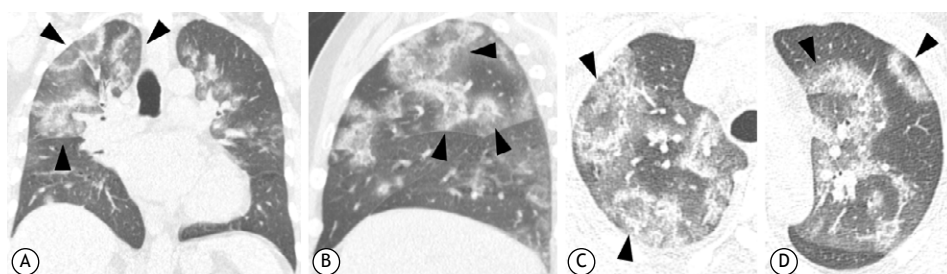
Images in coronal (A), sagittal (B), and axial (C and D) reconstructions from multidetector CT, showing multiple diffuse ground glass areas in both lungs, surrounded by partial or complete rings of consolidation, known as the reversed halo sign (arrows), in a 56-year-old male patient with COVID-19 pneumonia.
